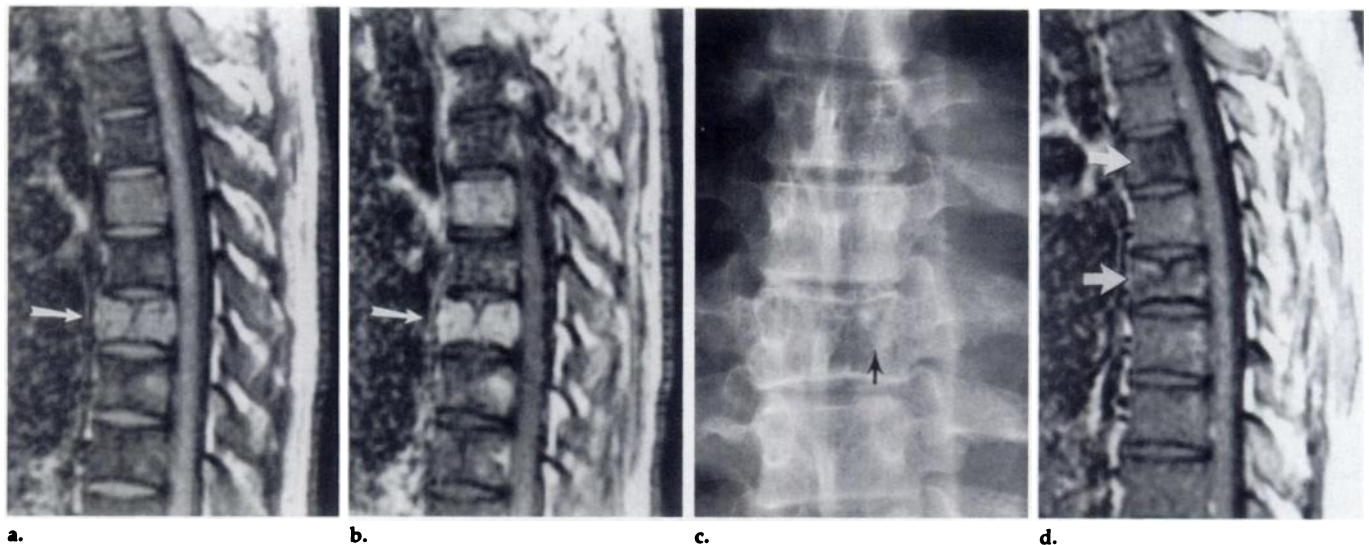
Symptomatic myeloma appearing as a focal pattern of marrow involvement in a 30-year-old man. (a) T1-weighted sagittal MR image (600/20) of the thoracic spine reveals an unusual hyperintense appearance of marrow involvement. The seventh dorsal vertebral body is compressed (arrow in a, b). There is slight impingement on the thecal sac. (b) T1-weighted postcontrast MR image (600/20) reveals enhancement of the lesions. (c) Radiograph of the thoracic spine reveals compression and myelomatous lesion in the seventh thoracic vertebral body (arrow). Involvement of the fifth thoracic vertebral body is also noted. (d) T1-weighted sagittal MR image (600/20) of the thoracic spine 13 months after treatment reveals focal lesions (arrows) appearing hypointense relative to muscle.
